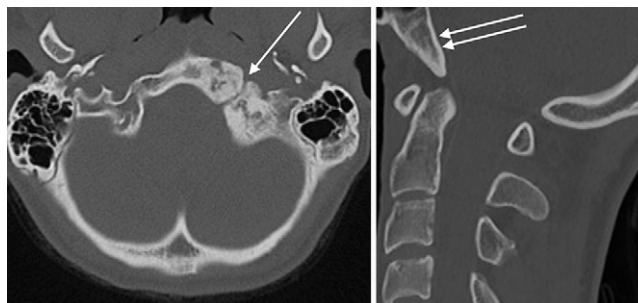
Noncontrast CT images obtained 3 years after the last treatment with locations matching those shown in Fig. 1. Left: Axial image showing dense ossification of the treated left side of the clivus and occipital condyle. The small hypoglossal canal (*arrow*) can now be seen traversing the previously treated area. Right: Midline sagittal image showing complete ossification (*double arrows*) of the previously cystic fluid-filled ABC component.
